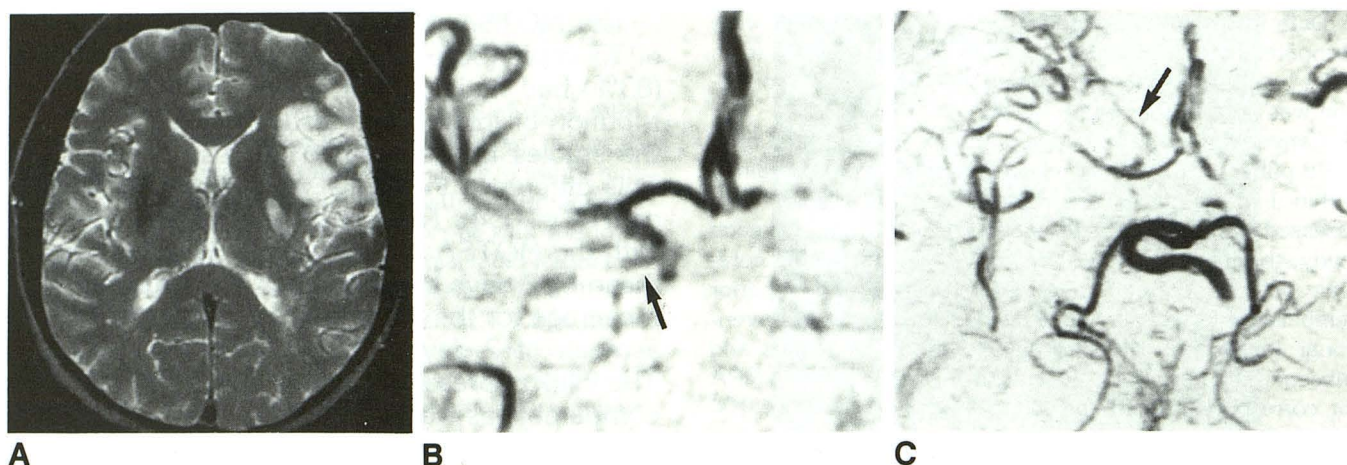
A, T2-weighted image shows a large infarction in the left middle cerebral artery distribution with lenticulostriate territory involvement, which suggests proximal MCA occlusion.
